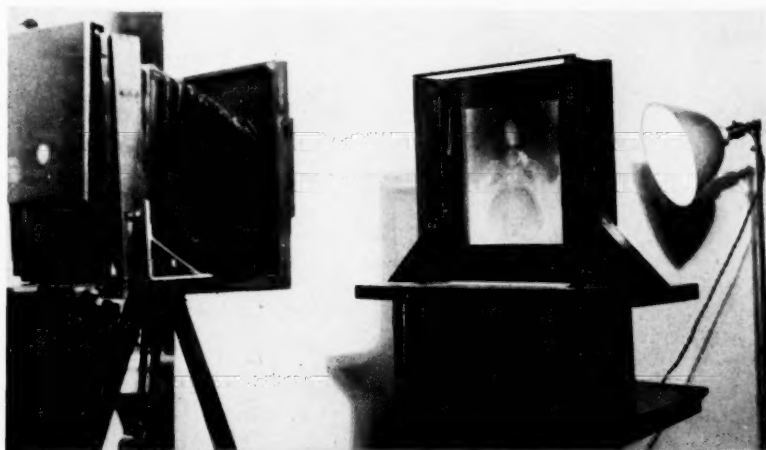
REPRODUCTION OF X-RAY FILMS
